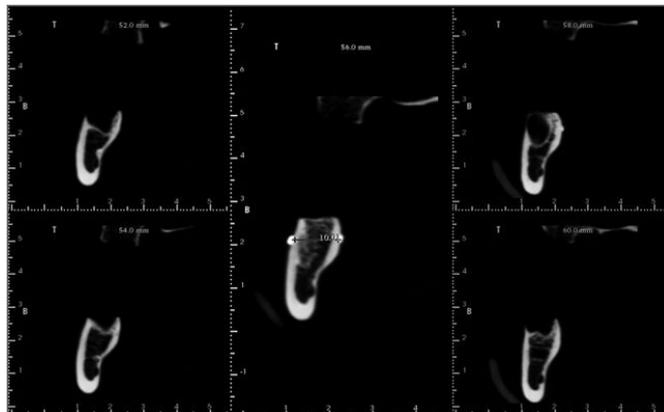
CBCT cross-sectional image of a marked mandibular edentulous site, which was digitally measured by using the imaging software.
